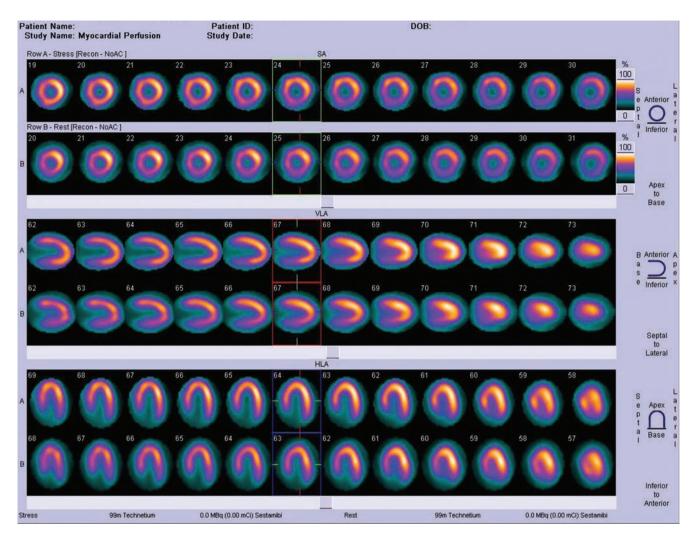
MIBI SPECT after 1 year
